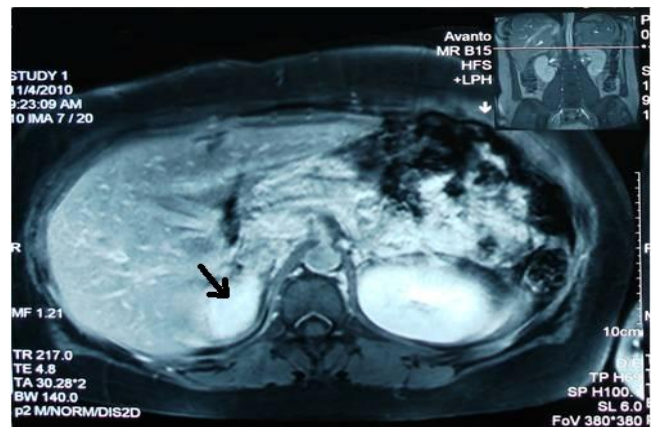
magnetic resonance imaging. Right adrenal mass
